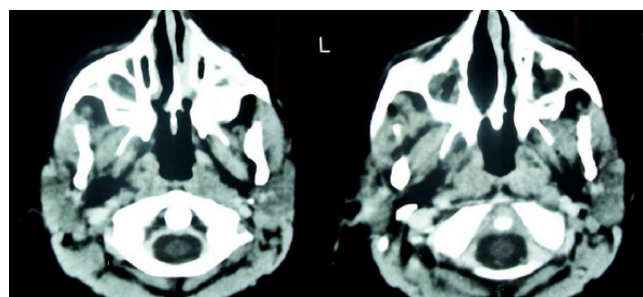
Axial paranasal sinus CT six months after the operation.
